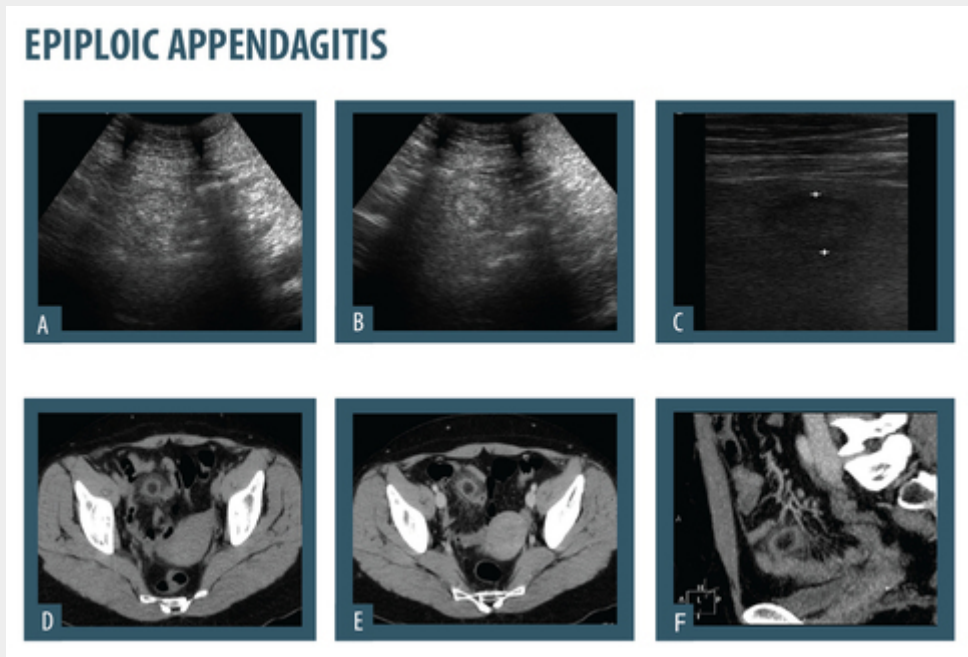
49 year-old patient presenting with lower quadrant pain, irradiating to the LLQ. On US (A,B,C) there is a rounded image, with thickened walls, non-compressible and painful with applied pressure of the transducer. On CT, this rounded lesion was localized in the antimesenteric surface of the colon and had central fat attenuation and showed peripheral enhancement. This was diagnosed as an epiplonic appendagitis.
